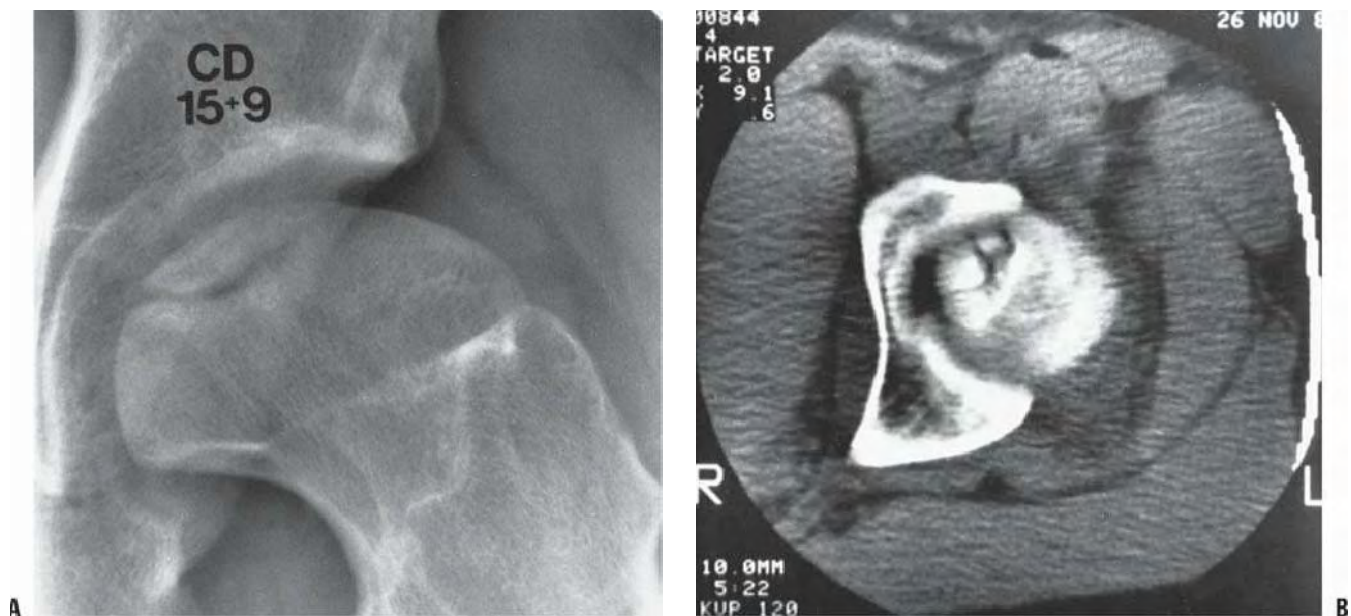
A: A 15-year-old boy, whose disease started at 8 years and 6 months of age, returned to the physician with pain and synovitis. AP radiograph demonstrates osteochondritis of the femoral head. B: Computed tomographic scan shows multiple fragments that appear as one on the radiograph.
